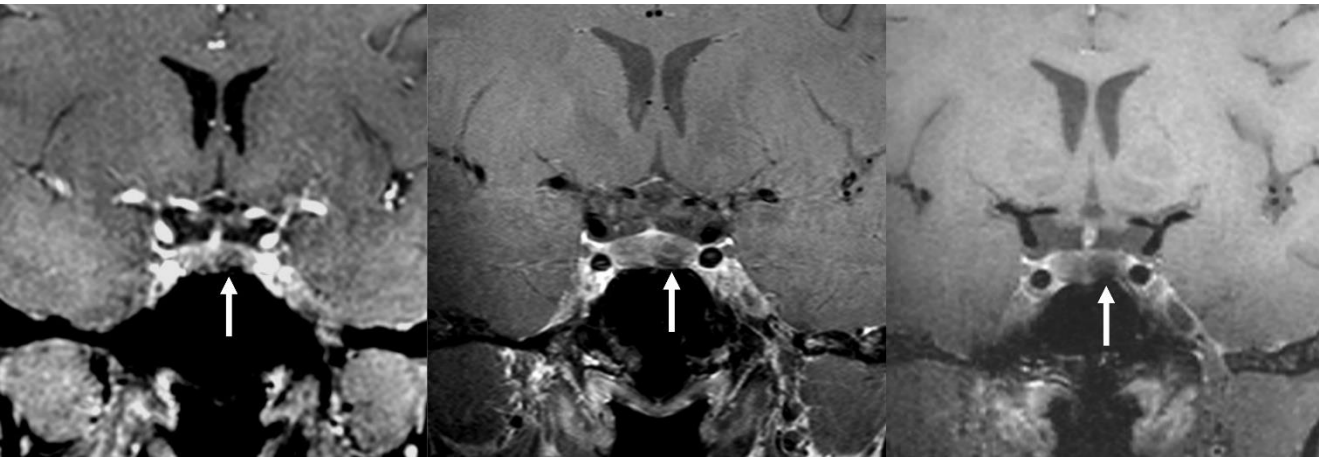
Three different types of 7T postcontrast T1-weighted imaging in a patient with a left sided pituitary adenoma (arrows): (L->R) DCE, 2D turbo-spin echo, and 3D SPACE with 1.5 mm, 1.5 mm, and 0.7 mm slice thickness respectively.
